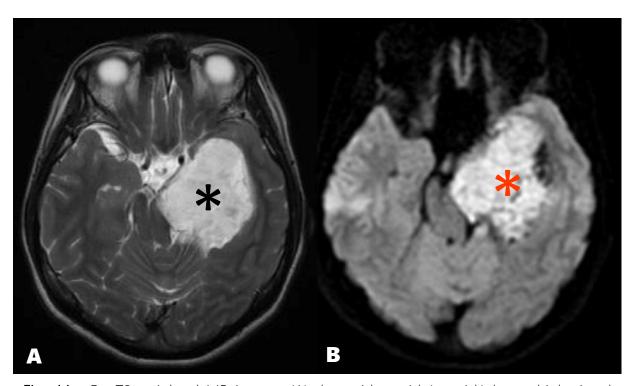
On T2-weighted MR images (A) the epidermoid (asterisk) has a high signal similar to CSF. On the DWI image (B), the epidermoid (asterisk) has a high signal because of restricted diffusivity allowing its differentiation from an arachnoid cyst. Arachnoid cysts have a low signal on DWI because diffusivity is not restricted as they contain CSE
